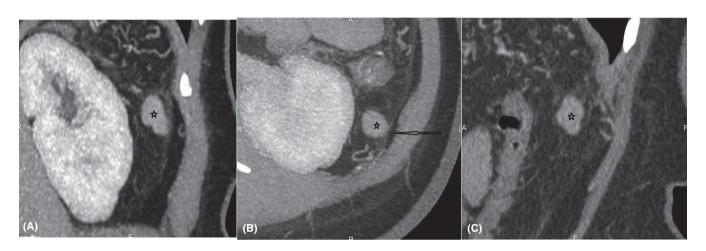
Ectopic focus of the spleen (marked with a star), has no feeding and diverting vessels, is attached to the parietal peritoneum (black arrow). CT images in the coronary, axial and sagittal planes, respectively
